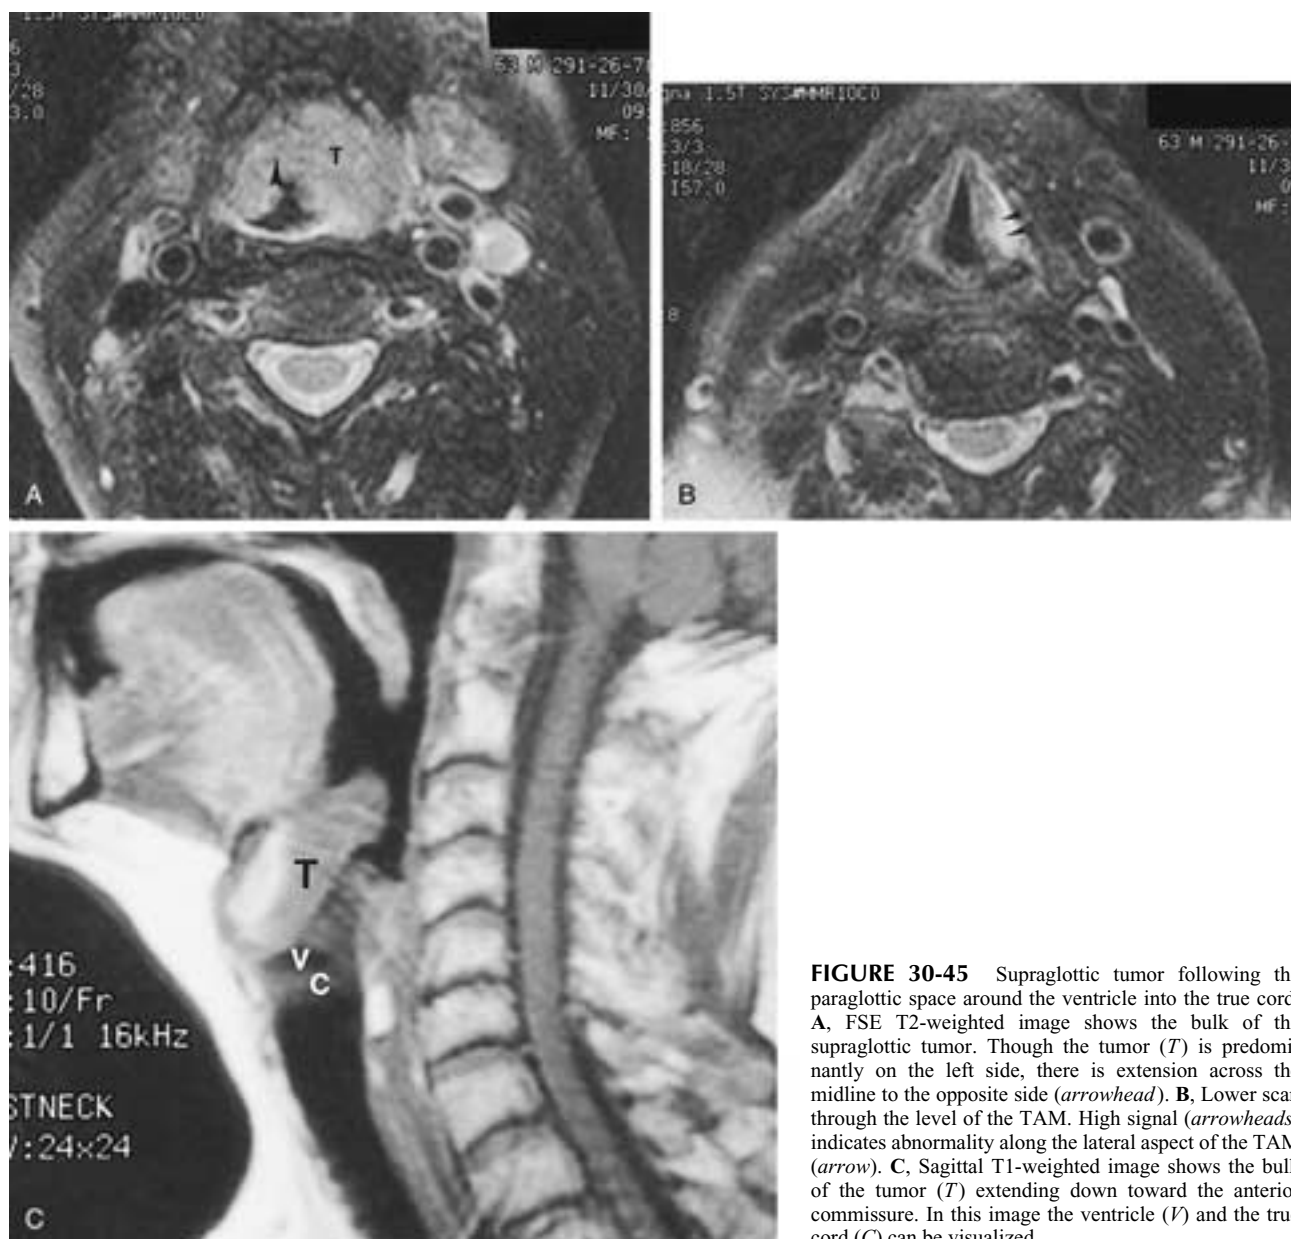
Supraglottic tumor following the paraglottic space around the ventricle into the true cord. A, FSE T2-weighted image shows the bulk of the supraglottic tumor. Though the tumor (*T*) is predominantly on the left side, there is extension across the midline to the opposite side (*arrowhead*). B, Lower scan through the level of the TAM. High signal (*arrowheads*) indicates abnormality along the lateral aspect of the TAM (*arrow*). C, Sagittal T1-weighted image shows the bulk of the tumor (*T*) extending down toward the anterior commissure. In this image the ventricle (*V*) and the true cord (*C*) can be visualized.
